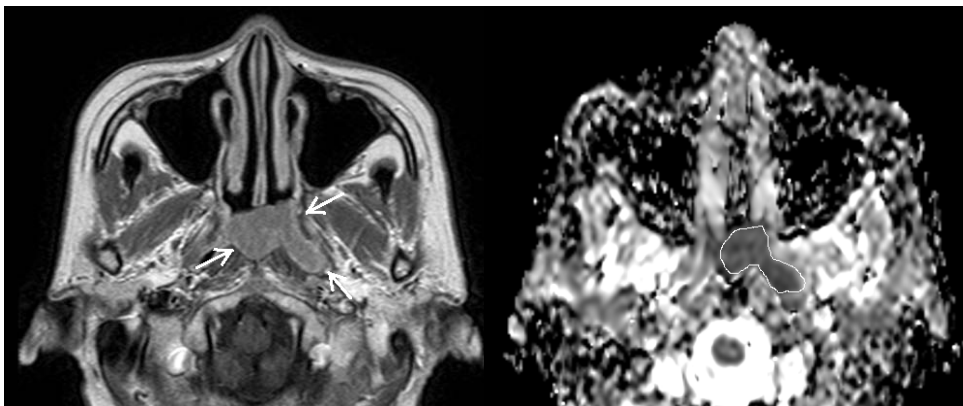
Post-contrast T1-weighted image (left) shows the primary tumor (arrow) and ADC map (right) shows the region of interest drawn around the primary tumor.
